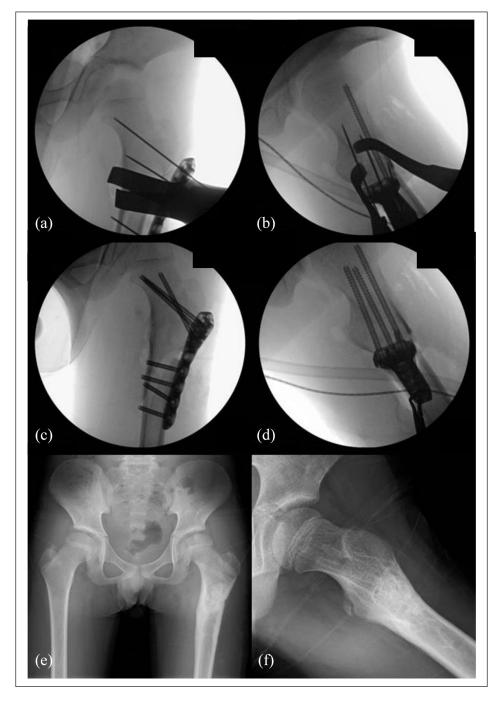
(a and b) Fluoroscopic images (a: anterior posterior view and b: lateral view) confirming the position where the plate could be installed for as many long screws as possible could be inserted without damaging epiphysis. (c and d) Fluoroscopic images (c: anterior posterior view and d: lateral view) showing the plate and screw installation positions. Three screws are inserted to stabilize the proximal bone fragment, while penetrating the pathological lesion without damaging the epiphysis. (e and f) Radiographs (e: anterior posterior view and f: lateral view) at 12 months after surgery showing that the fracture site is fused, and bone formation is observed within the pathological lesion. No obvious growth failure was noted at this time.
